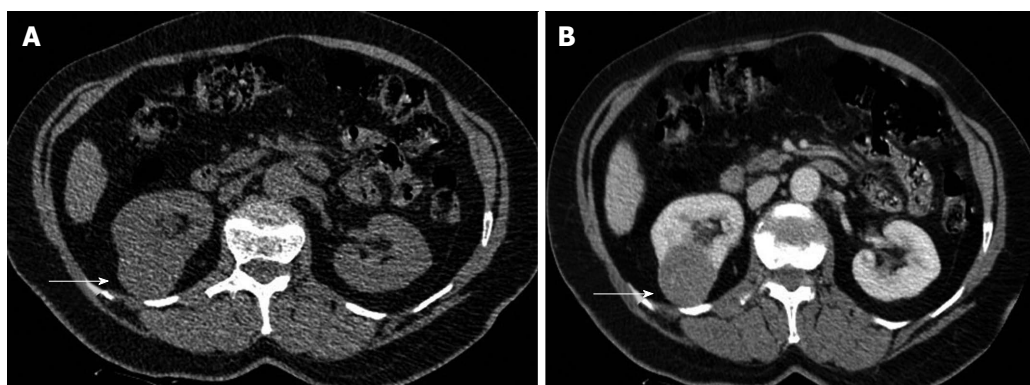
The 60-year-old woman with clear cell renal cell carcinoma of the left kidney (stage T1a, grade II). A: Transverse plain computed tomography (CT) image depicts lower pole right renal mass as a focal bulging of the renal contour (arrow), mainly isodense (CT density: 35 HU) to the renal parenchyma; B: Axial multiplanar reformation during the corticomedullary phase clearly shows renal malignancy (arrow) moderately and heterogeneously enhancing (mean CT density: 60 HU). Heterogeneous contrast enhancement on imaging should always suggest renal malignancy preoperatively.
